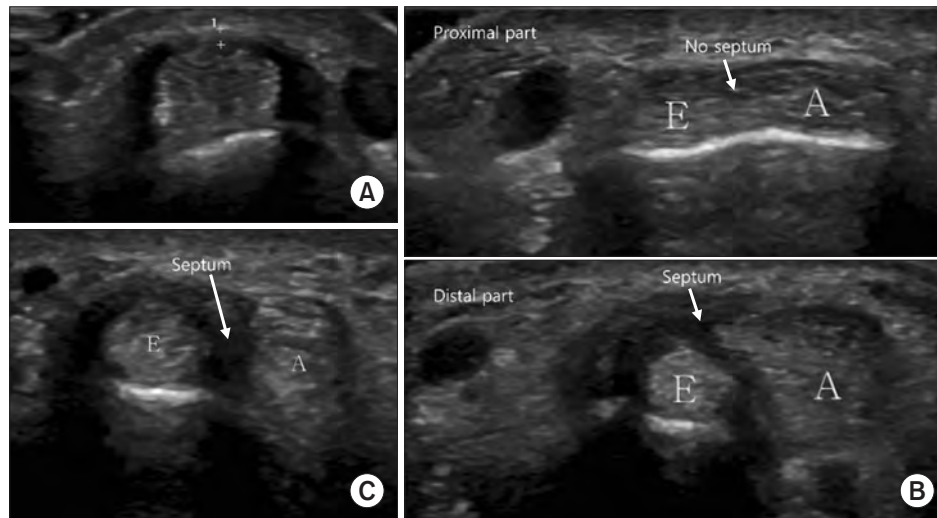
The sonographic images visually represent the varying degrees of subcompartmentalization within the first extensor compartment of the wrist, specifically focusing on the presence or absence of a septum. E: extensor pollicis brevis, A: abductor pollicis longus. (A) The “no septum” section shows the extensor pollicis brevis and abductor pollicis longus tendons appearing as 1, with no visible septum, indicating no subcompartmentalization. (B) Ultrasonographic images of an incomplete septum. The proximal part (upper image) shows no septum (arrow) between the abductor pollicis longus and extensor pollicis brevis tendons, while the distal part (lower image) displays a septum (arrow) partially dividing the first extensor compartment. (C) Ultrasonographic image of a complete septum. An arrow indicates the septum fully separating the abductor pollicis longus and abductor pollicis longus tendons into distinct subcompartments throughout the entire length of the first extensor compartment.
